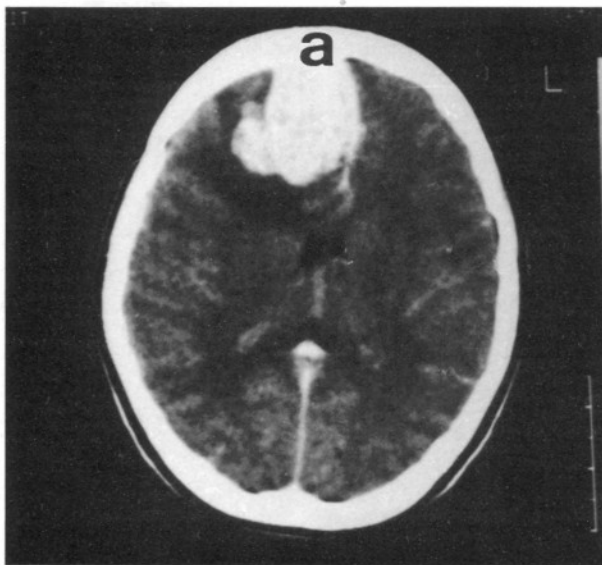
a) Preoperative CT scan of Case 2 showing a right-sided, frontal, hyperdense mass after contrast injection, b) after total excision of the tumor.
